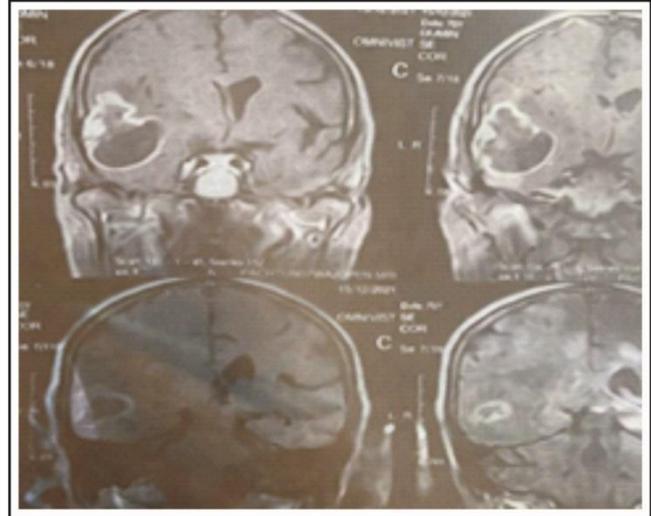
Coronal MRI of Patient X demonstrating a Temporoparietal Glioma in a 70-Year-Old Patient (Image used with patient's permission).
